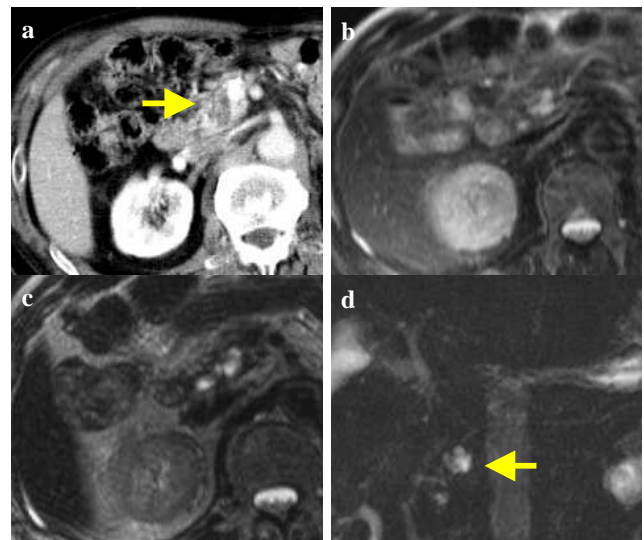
Cystic pancreatic tumor. (a) Arterial-phase CT shows a low-attenuated lesion (arrow) in the pancreatic head. Differential diagnosis (cystic versus non-cystic) may be difficult. (b) T2-weighted image. (c) Heavily T2-weighted image. (d) MRCP. Comprehensive MR images reveal a cystic tumor (arrow) in the pancreatic head with confident diagnosis.
